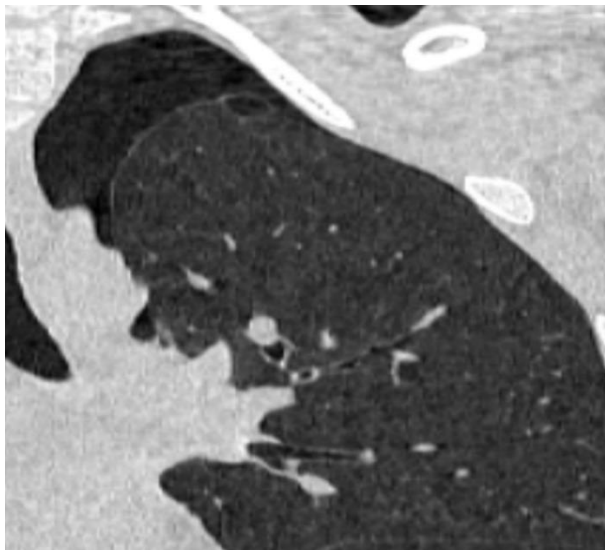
Coronal CT image showing Lt apical bulla and Lt pneumothorax.
